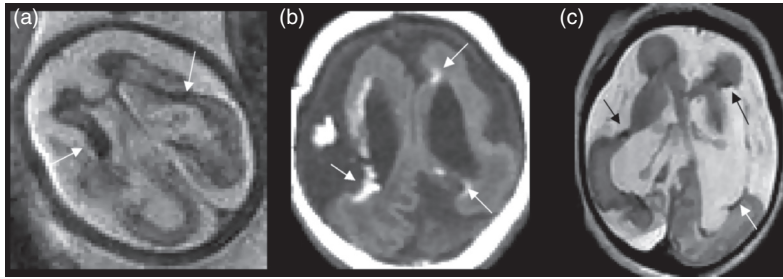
Congenital CMV on (a) fetal T2 and (b) neonatal T1 + (c) GRE MRI including dysplastic (microcephaly, undergyration) and encephaloclastic (cavitations) components plus T1 hyperintense/T2 hypointense mineralization (arrows).
